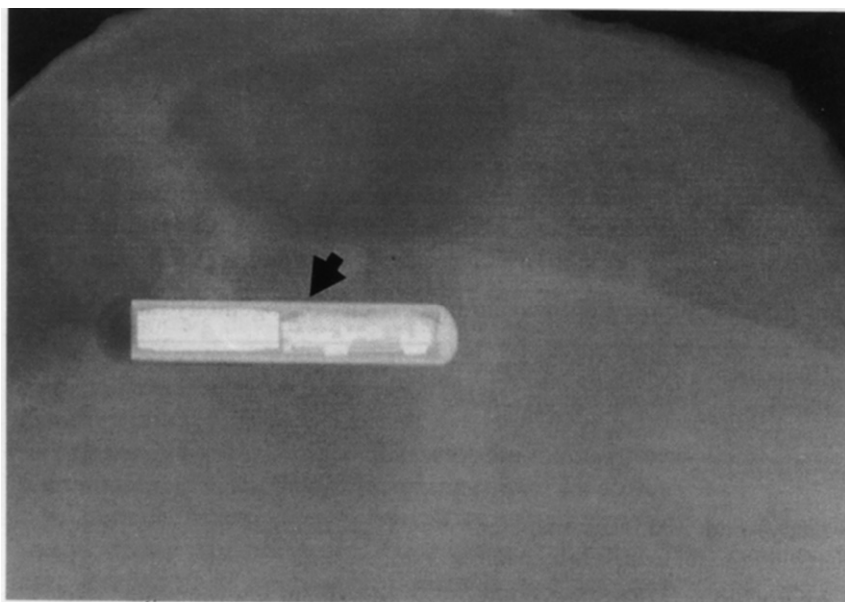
Radiograph of an in-situ microchip device (arrow) surrounded by a semi-radiopaque mass (female #1111).
